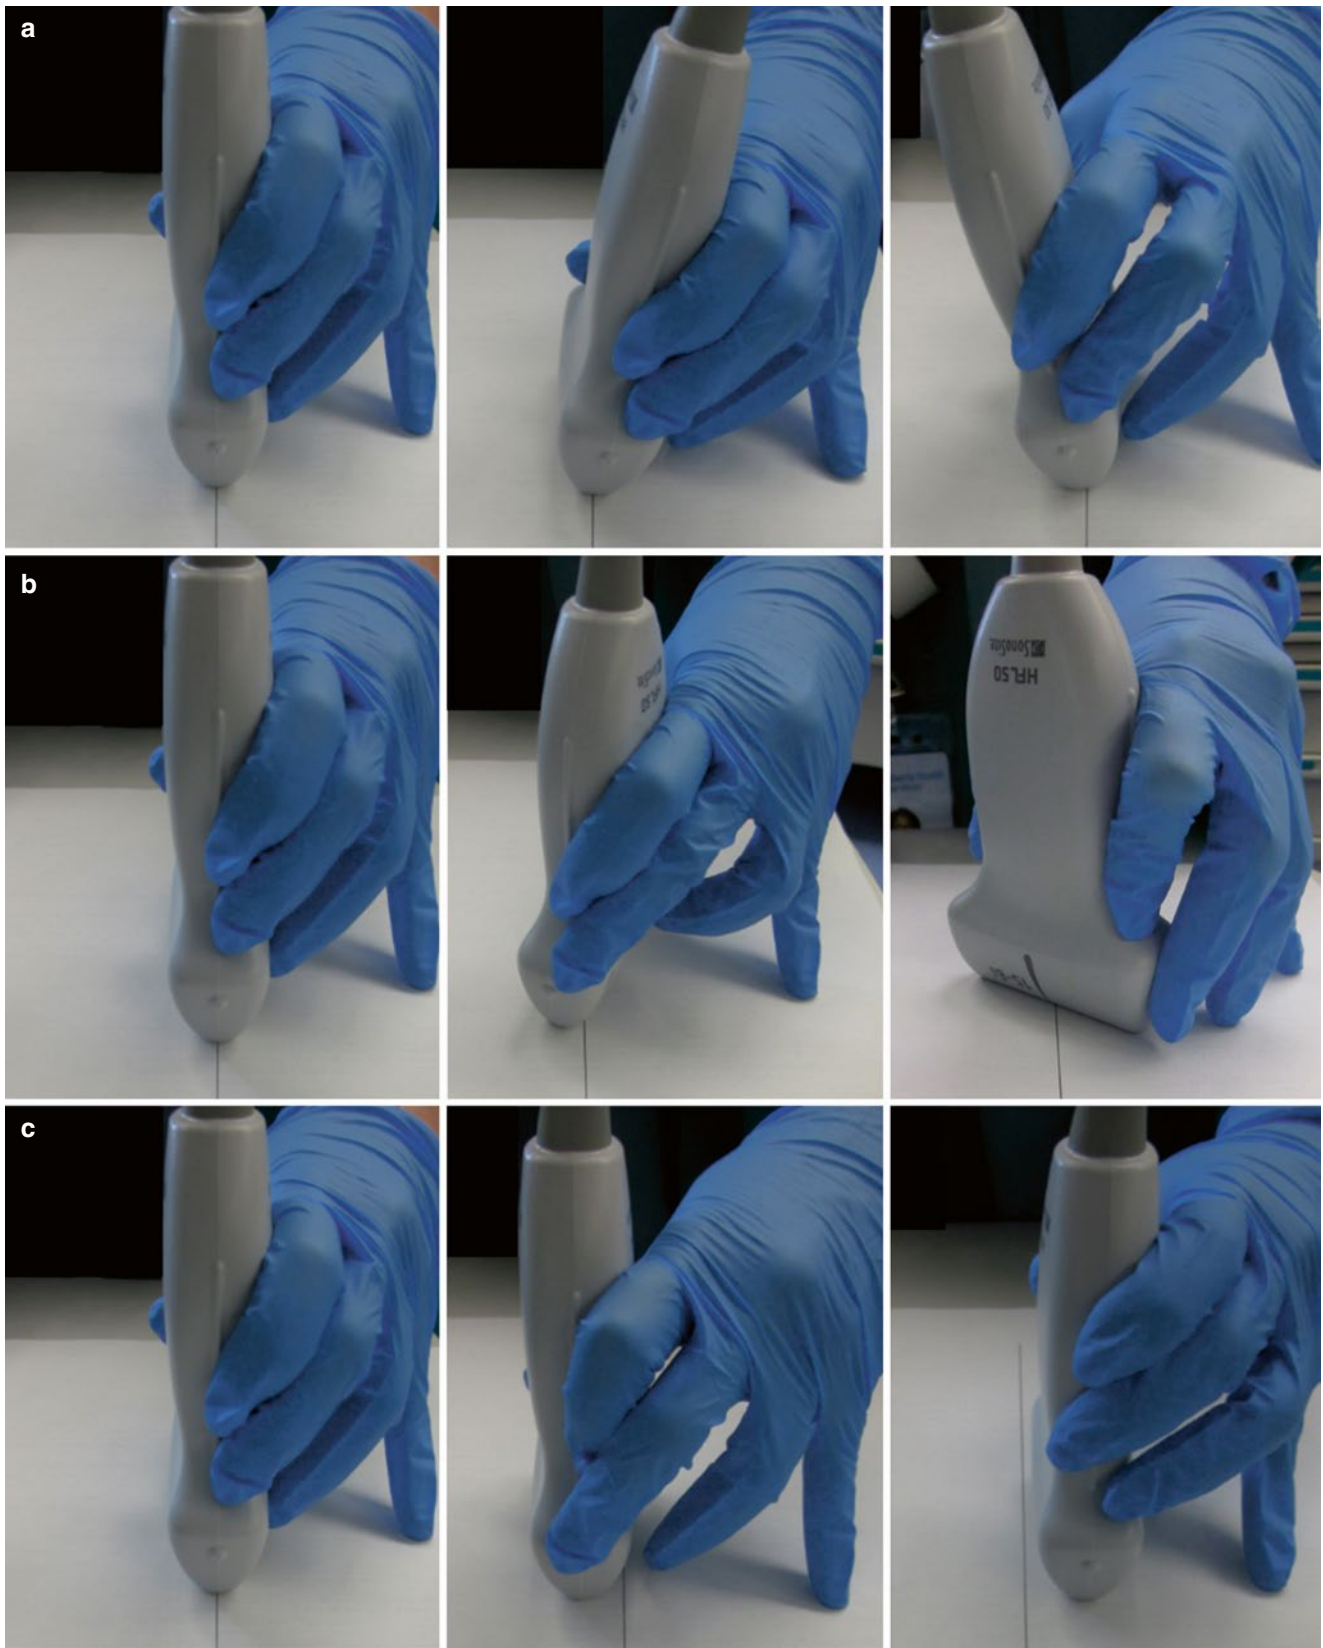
Tilting (a), rotating (b), and manipulating (c) the alignment of the ultrasound probe is necessary to visualize the tip of the needle. The *line* on the paper indicates the original axis of the probe
